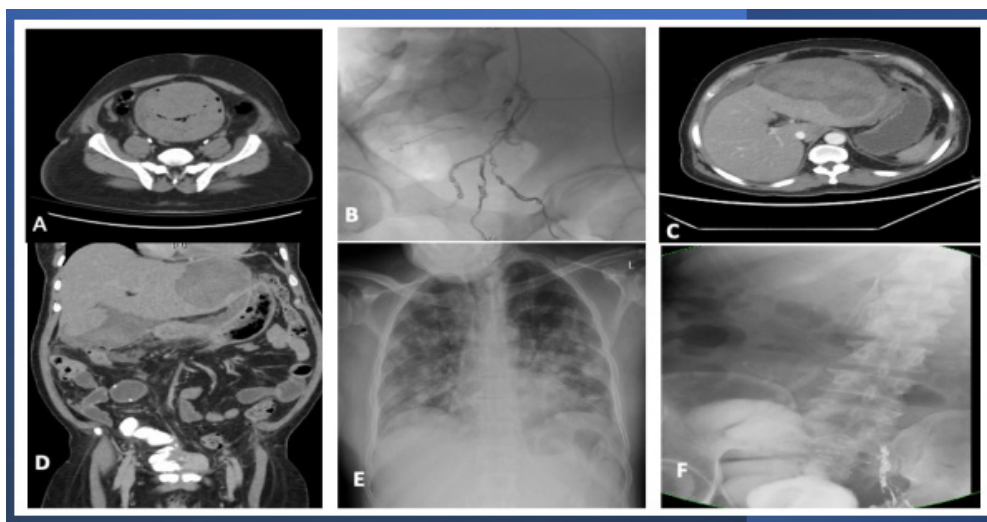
Radiological Findings of the Epithelioid Angiosarcoma of the Urinary Bladder. A), CT scan findings include a marked thickening of the wall of the urinary bladder and distension of its lumen by blood clots; B), Selective Angioembolization of left vesical vessels and angioembolization of the anterior branch of the left internal iliac artery; C-D), CT scan with IV contrast post radical cystoprostatectomy and studor ileal neobladder revealing a huge hepatic subcapsular hematoma; E), Follow-up CXR, CT chest revealed the development of metastasis in the lungs; F), post radical cystoprostatectomy follow up with pouchogram, the placement of IVC filter and angioembolization.
